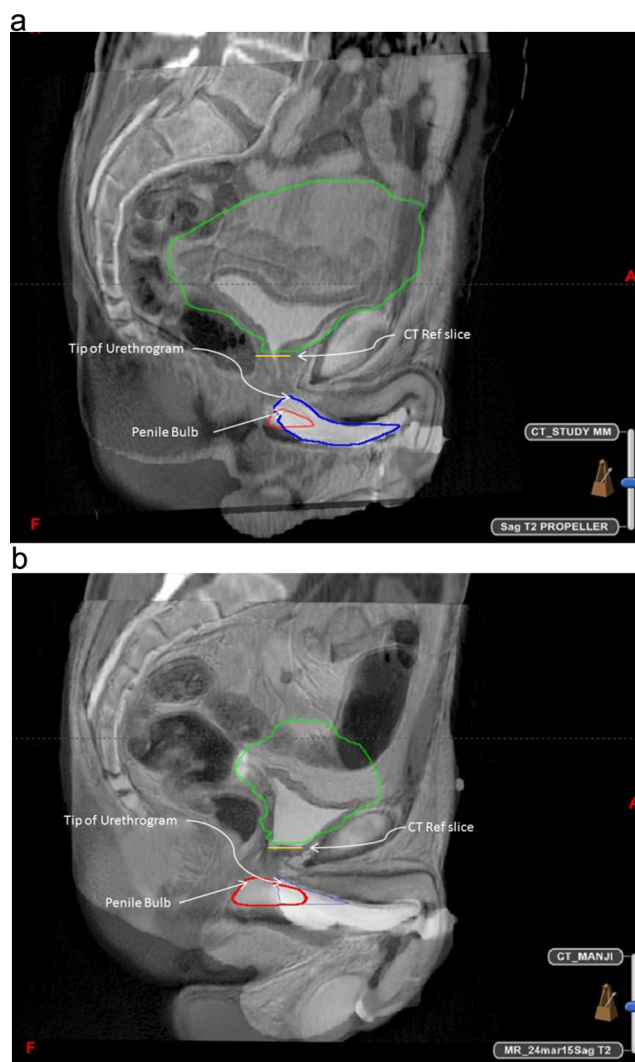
MR-CT fusion showing tip of urethrogram cone (identified on CT), penile bulb (identified on MRI), and CT Reference Slice (yellow line). The bladder is visible on MR and the bladder contour from the CT is superimposed. (a) Penile bulb is 8 mm caudal to tip of urethrogram cone, and 2.8 cm caudal to the Bladder CT Reference Slice. In this example, the caudal aspect of the EORTC CTV falls half way between the penile bulb and the Bladder CT Reference Slice. (b) Penile bulb is level with the tip of the urethrogram cone, and 1.6 cm from the Bladder CT Reference Slice. In this case, the caudal aspect of the EORTC CTV would be 1 mm caudal to the Bladder CT Reference Slice.
